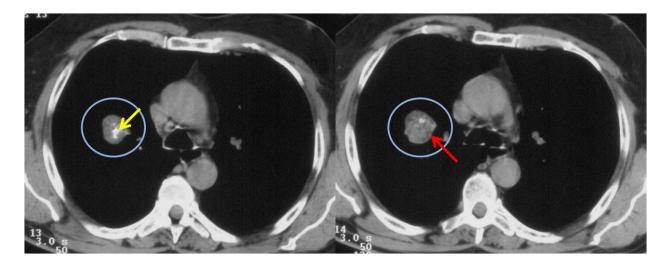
Hamartoma. Chest CT scan images show a heterogeneous, sharply marginated lesion with focal areas of calcification (yellow arrow) and fat (red arrow). These findings are typical features of hamartoma.
